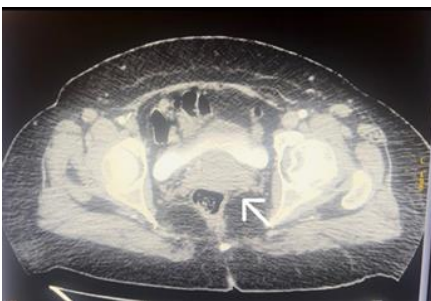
CT of the abdomen and pelvis with intra-venous contrast suggested endometrial carcinoma with no evidence of regional/metastasis lymphadenopathy.
